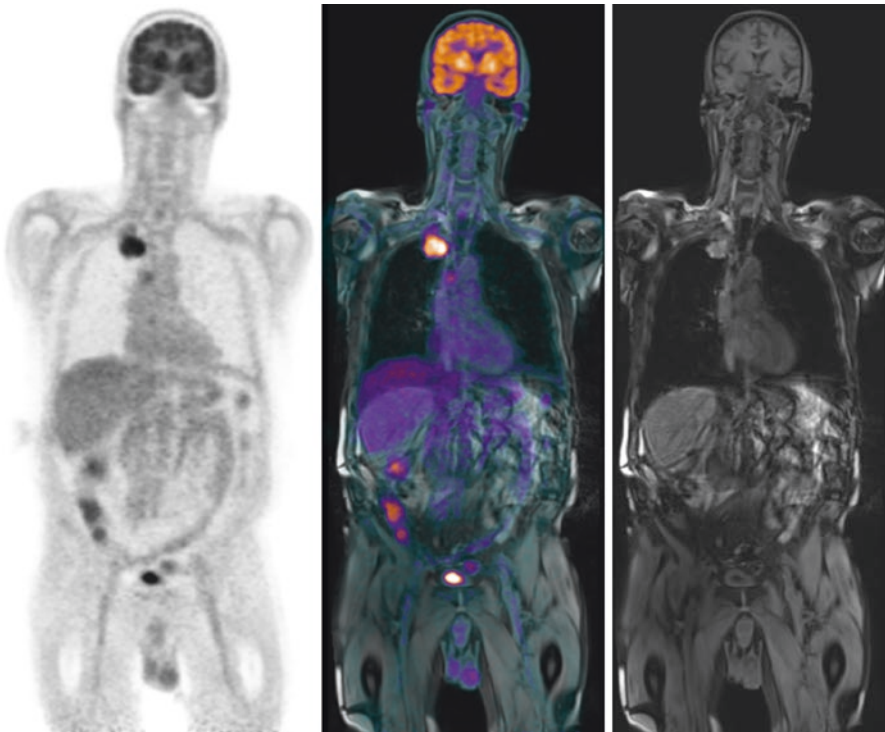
^{18}F -FDG whole body PET/MR showing PET, PET/MR fused and MR in the coronal plane
